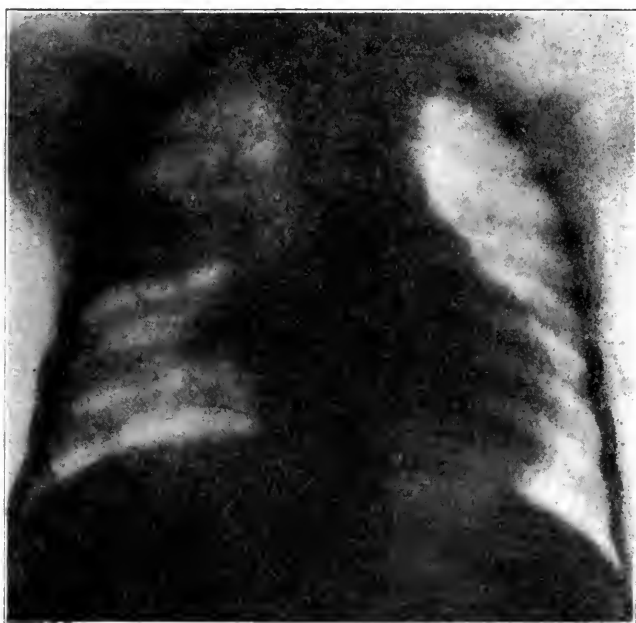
X-ray of Case 3, showing the shadow in the outer portion of the thorax.
